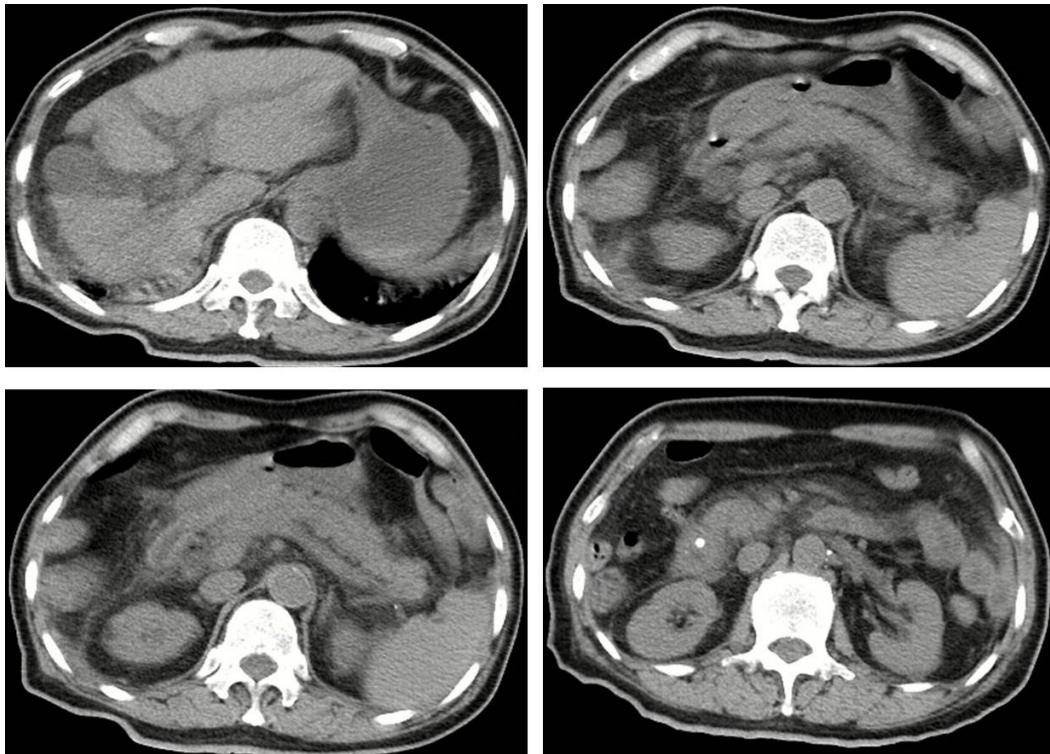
Abdominal CT scans at this Hospital on April 2, 2018 showing liver cirrhosis, abnormal morphology of the pancreas, ascites, and cholelithiasis.
